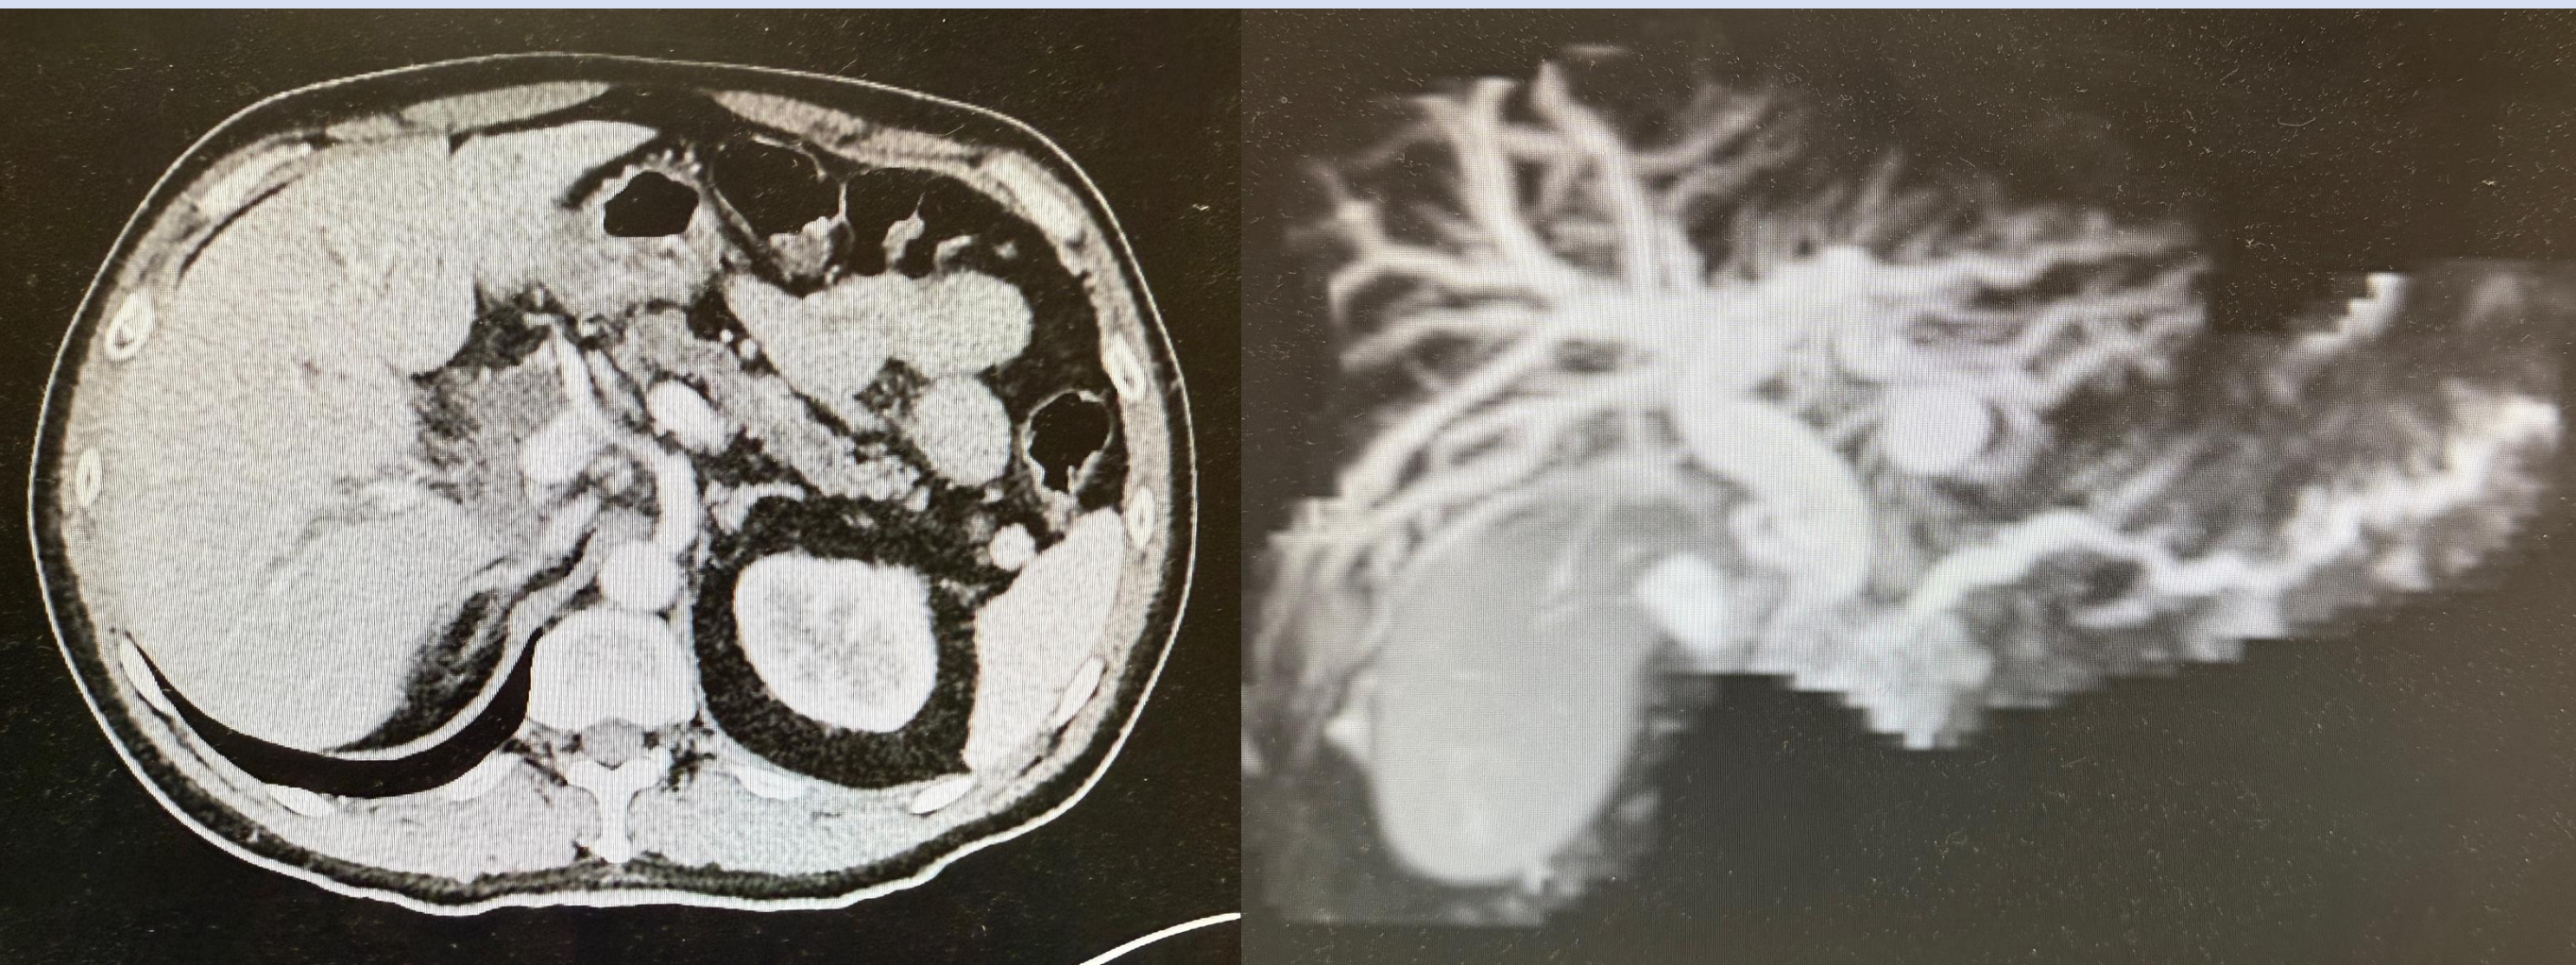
(a) CT abdomen and pelvis showing a low attenuating heterogeneous mass in the pancreatic head measuring 4.4 x 4.3 x 3.8 cm concerning for neoplasm with dilation of the pancreatic duct and both intra and extrahepatic biliary ducts. (b) MRCP showing a complex cystic-solid mass measuring 4.9x4x3.8 cm with mass effect on the CBD and pancreatic duct dilation to 4mm at its tail.
